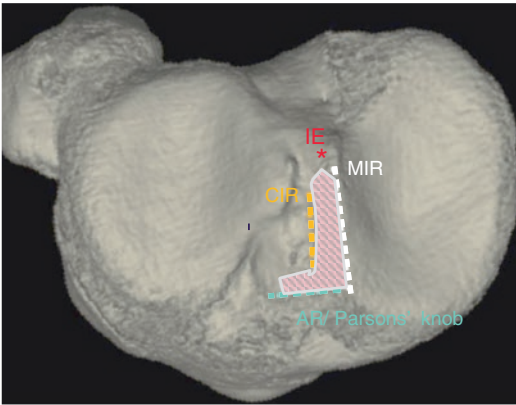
ACL tibial attachment area of boot shape on 3-D CT of the right knee. There are 4 bony landmarks to identify the area: *MIR* medial intercondylar ridge, *AR* anterior ridge, *CIR* central intercondylar ridge, *IE* intercondylar eminence
